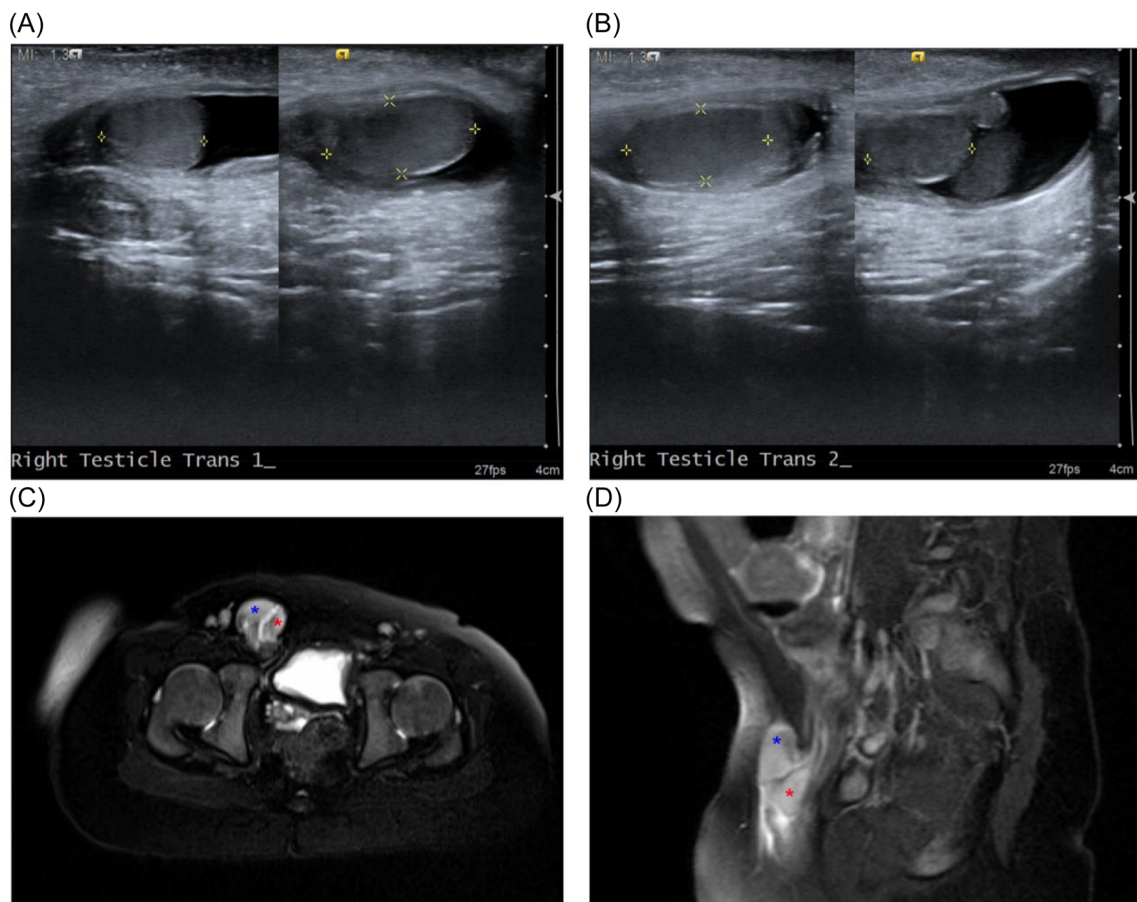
Preoperative scrotal ultrasound and Pelvic MRI without contrast. (A) Transcrotal ultrasound of testicle 1 in the right hemiscrotum; (B) transcrotal ultrasound of testicle 2 in the right hemiscrotum; (C) pelvic MRI axial view; (D) pelvic MRI sagittal view. The blue star represents testicle 1 and the red star represents testicle 2. MRI, magnetic resonance imaging.
